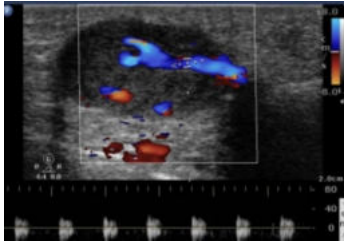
Ultrasound showing complete lumen occluding thrombus
